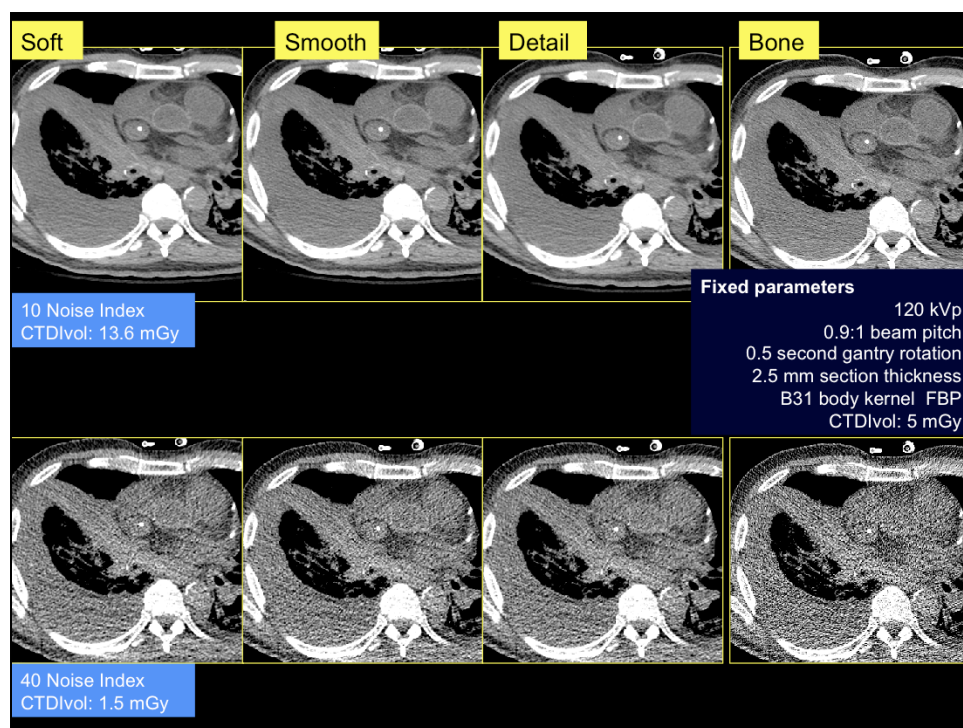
Transverse chest CT images in mediastinal windows acquired at two dose levels (higher dose)
